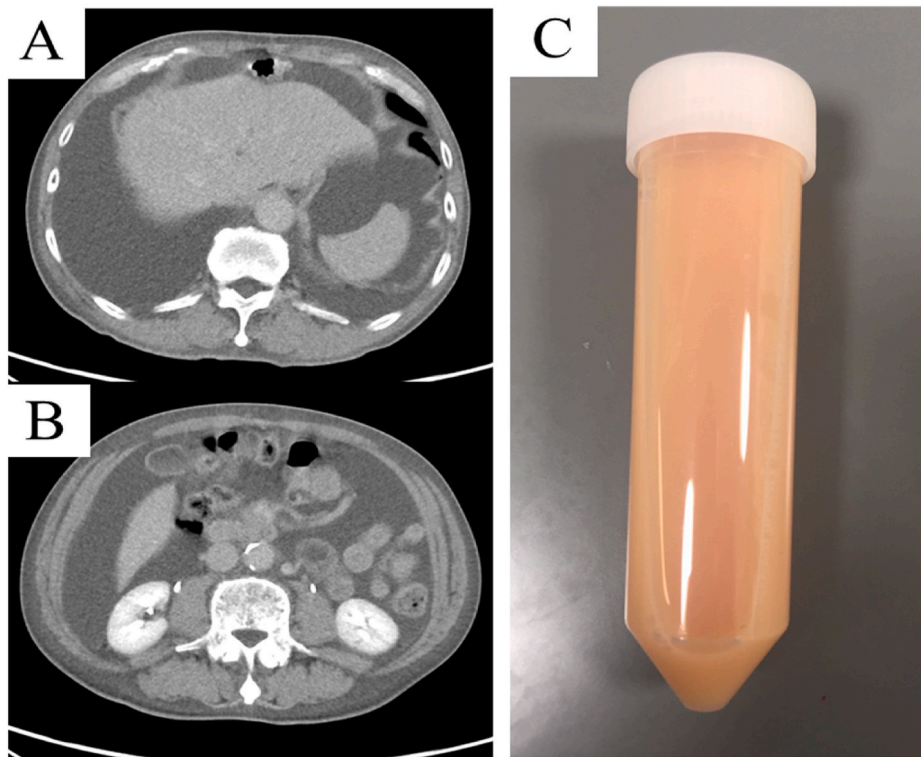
(A–B) Abdominal computed tomography reveals ascites. (C) Ascites aspirated through abdominocentesis upon admission demonstrates chylous ascites.
